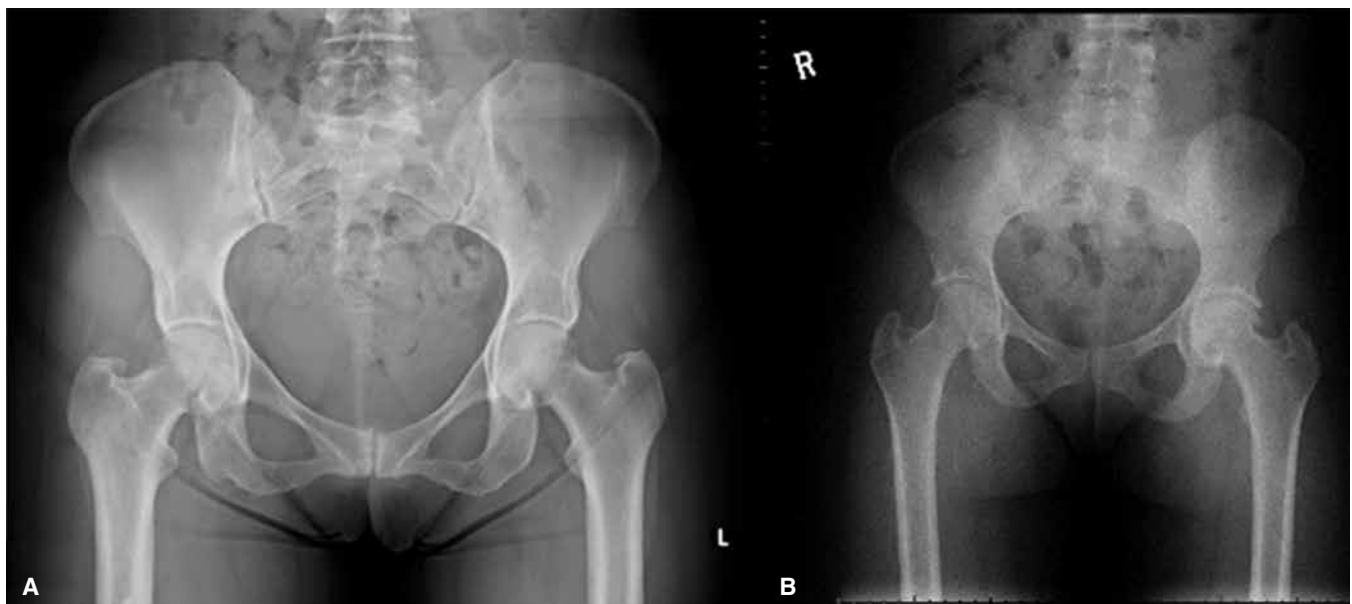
(A) Supine AP pelvis radiograph of a 54-year-old female revealing protrusio as both the acetabular fossa and the femoral head lie medial to the ilioischial line. (B) Supine AP pelvis radiograph of a 34-year-old female revealing profunda of the right hip joint and pincer type FAI as the acetabula fossa abuts the ilioischial line, causing overcoverage of the femoral head and FAI from pincer type morphology.
